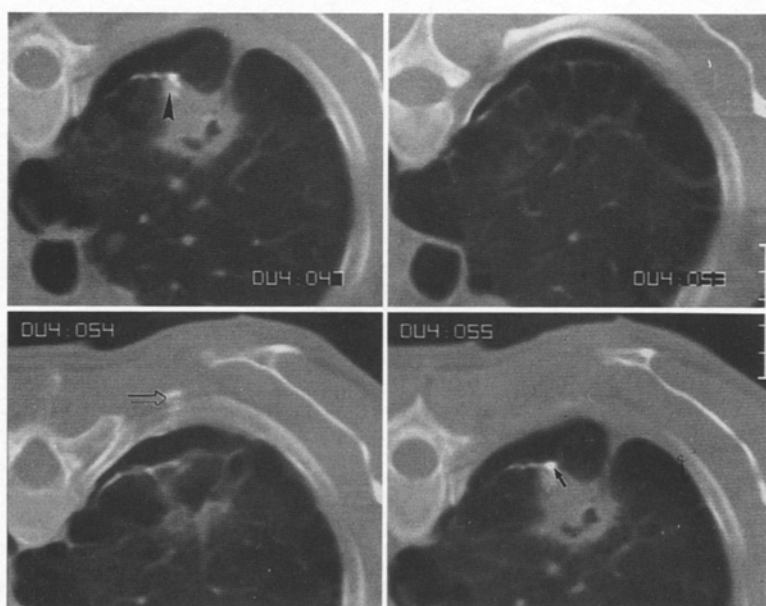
Thoracic CT scans in a patient with a lung carcinoma surrounded by multiple subpleural emphysematous bullae, because of which the only possible biopsy route had to pass through the emphysematous area. Note the fibrin-glue plug (intense white due to the contrast medium) which occupies the pierced bulla (arrowhead) and also seals the point of entry (arrow). The open arrow points to residual sealant in the chest wall indicating the biopsy route. The limited pneumothorax, shown at 10 min post-biopsy, remained stable.
